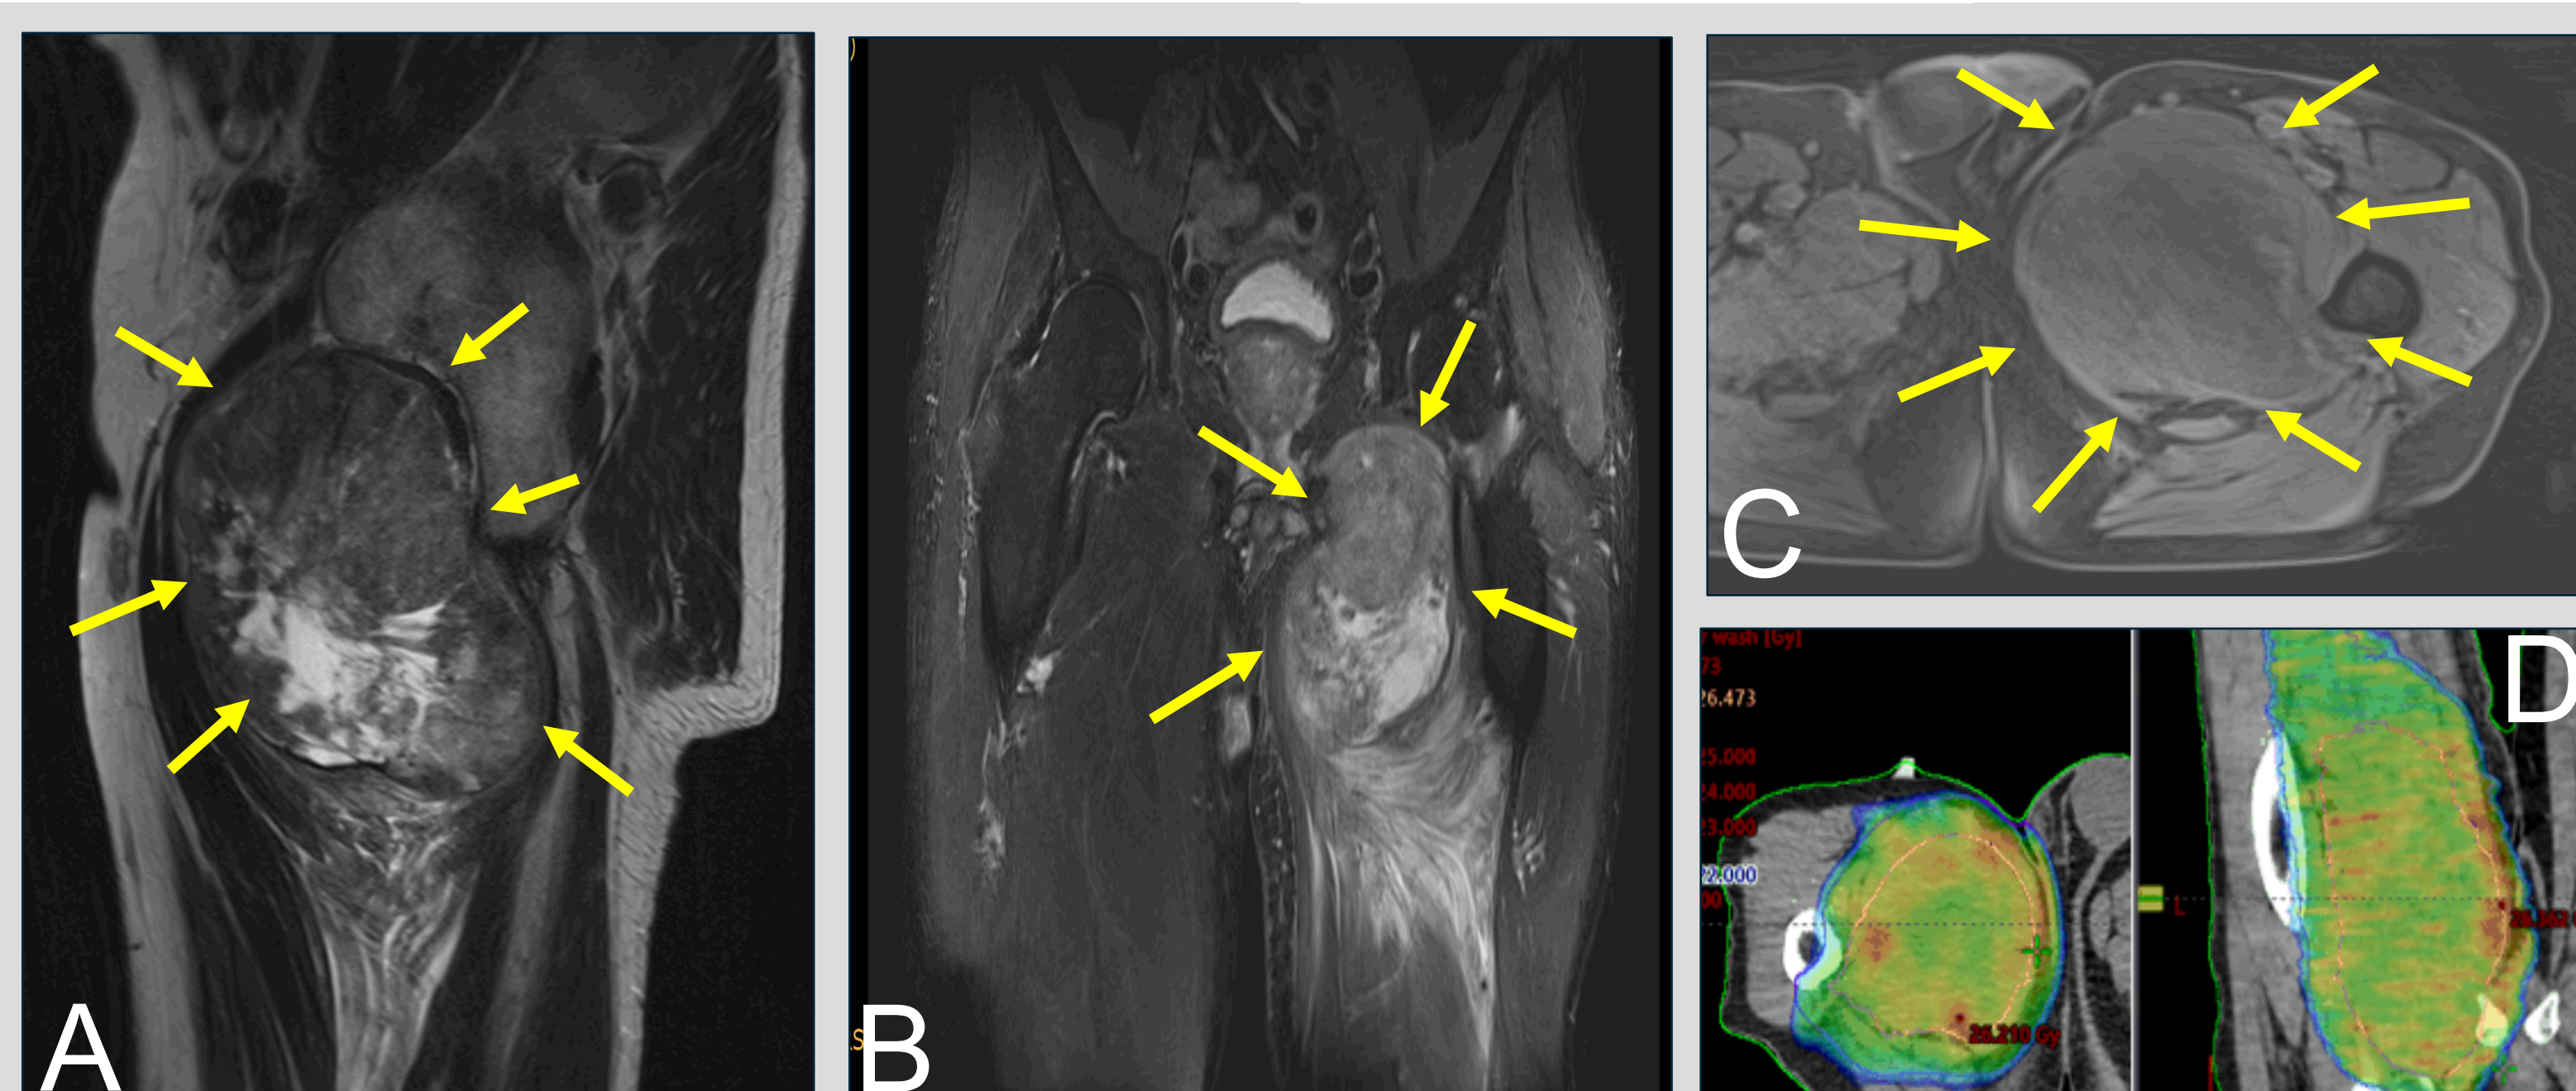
(A) Sagittal, (B) coronal and (C) axial MRI slices of tumor in the left adductor compartment (arrows). (D) Planning of preoperative radiation.
